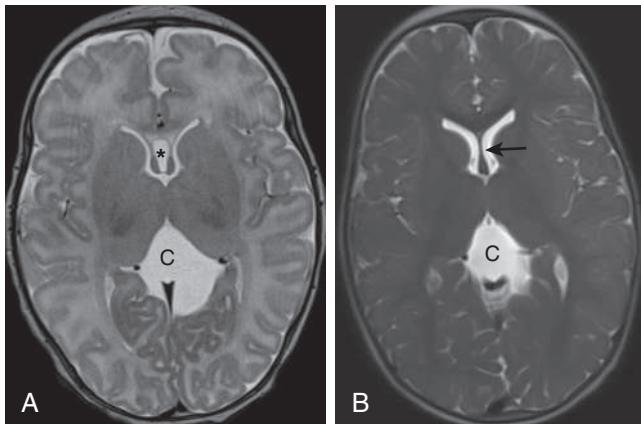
Age-expected evolution of the septum pellucidum. Throughout fetal life, the septum pellucidum exists as paired leaflets enclosing a midline CSF space. This configuration is known as a cavum septum pellucidum and undergoes fusion into a single membrane during the first months of postnatal life. A, A brain MRI axial T2-weighted image of a 42-day-old female followed for a cistern of the velum interpositum cyst (C) demonstrates normal separation of the septal leaflets with an intervening CSF pocket, the cavum septum pellucidum (asterisk). B, An axial single-shot T2-weighted brain MR image at 13 mo in the same patient demonstrates expected fusion of the leaflets into a single membrane (arrow).
